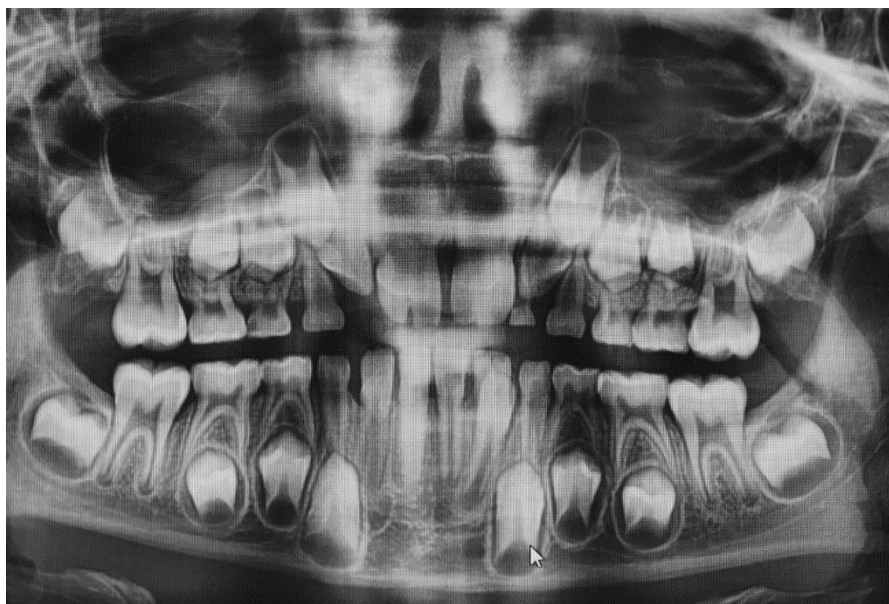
Preoperative panoramic x-ray of the patient.
